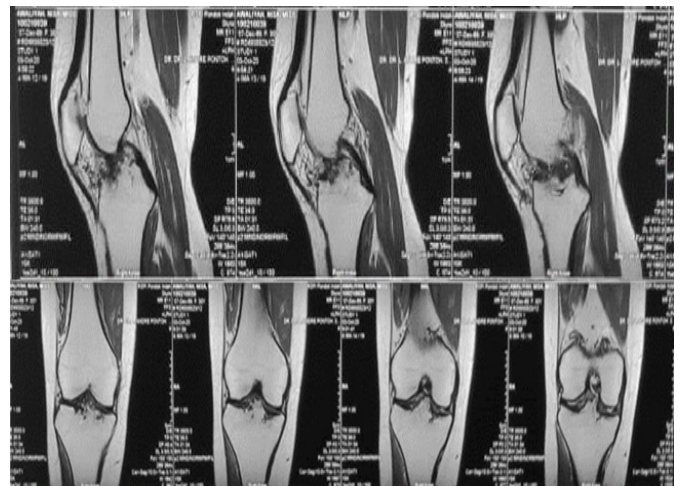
MRI showed a large tibial spine fracture in malunited position with extended fragment on posterior hinge
